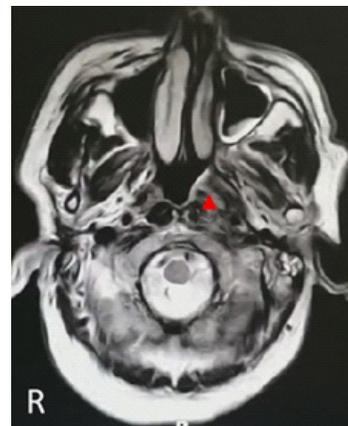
Representative coronal sections of a pre-antifungal treatment MRI nasopharynx with contrast demonstrating the pharyngeal recess disappeared and bulged out (red triangle Δ).
